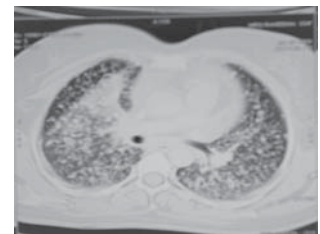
HRCT demonstrates multiple small interstitial nodules with central hypodensity and a wedge shaped consolidation in right upper lobe.
